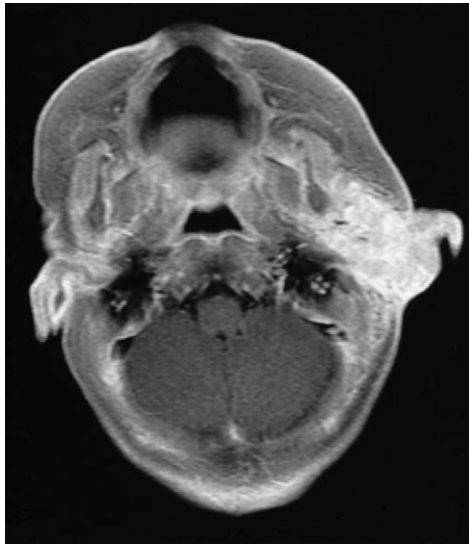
Patient 7: Postgadolinium axial magnetic resonance imaging through level of parotid showing inhomogeneous tissue enhancement that extends along multiple tissue planes with subcutaneous stranding and small flow voids.
